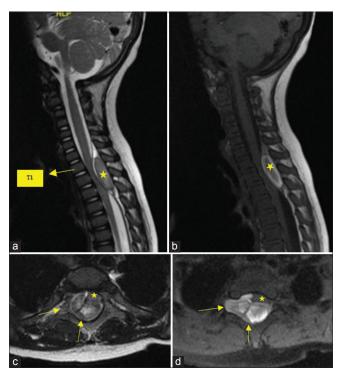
(a and b) are sagittal T2, T1 Magnetic resonance imaging (MRI) images showing upper thoracic spinal epidural hematoma (SEH) (star) extending from T1 level (arrow) to T3 with significant spinal cord compression. (c and d) are axial T1, T2 MRI showing SEH involving the posterior and right anterolateral aspects of the spinal canal at T2 level with extension of the hematoma to the right T2–T3 neural foramina (arrows). The spinal cord compressed with a left anterolateral displacement of the cord (star).
